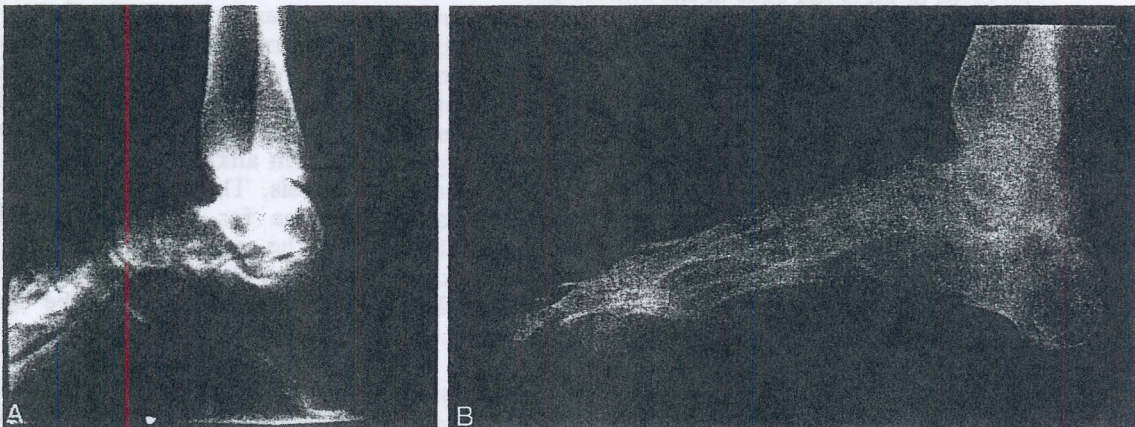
Combined forefoot and hindfoot cavus due to poliomyelitis. (A), The preoperative radiograph. Correction was performed using a posterior calcaneal osteotomy to decrease the calcaneal pitch and simultaneous distraction of the forefoot from the hindfoot, as well as elevation of the forefoot upward by pulling from the tibial ring. It should be noted that the rate of distraction of the forefoot upward should be approximately two times the rate of distraction of the forefoot away from the hindfoot. This is based on a mathematical calculation. (B), The final radiograph demonstrating the correction of the hindfoot and the forefoot equinus. (Courtesy of Dror Paley, M.D.)
